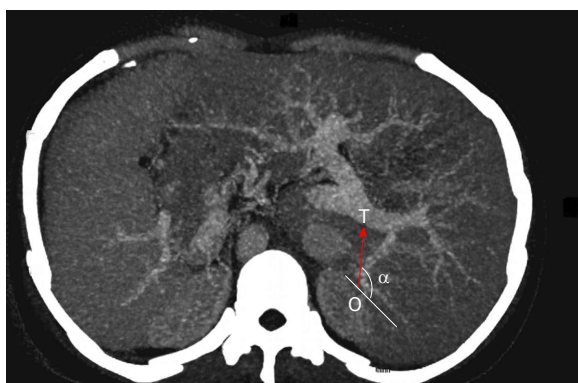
Determination of rotation angle for puncture set. Contrast-enhanced computed tomography image in Figure 1 is rotated 180 degrees, and the angle between the direction given by the extension line that links the two puncture points and direction of the right vein (red arrow) is the rotation angle (α) for the puncture set.
